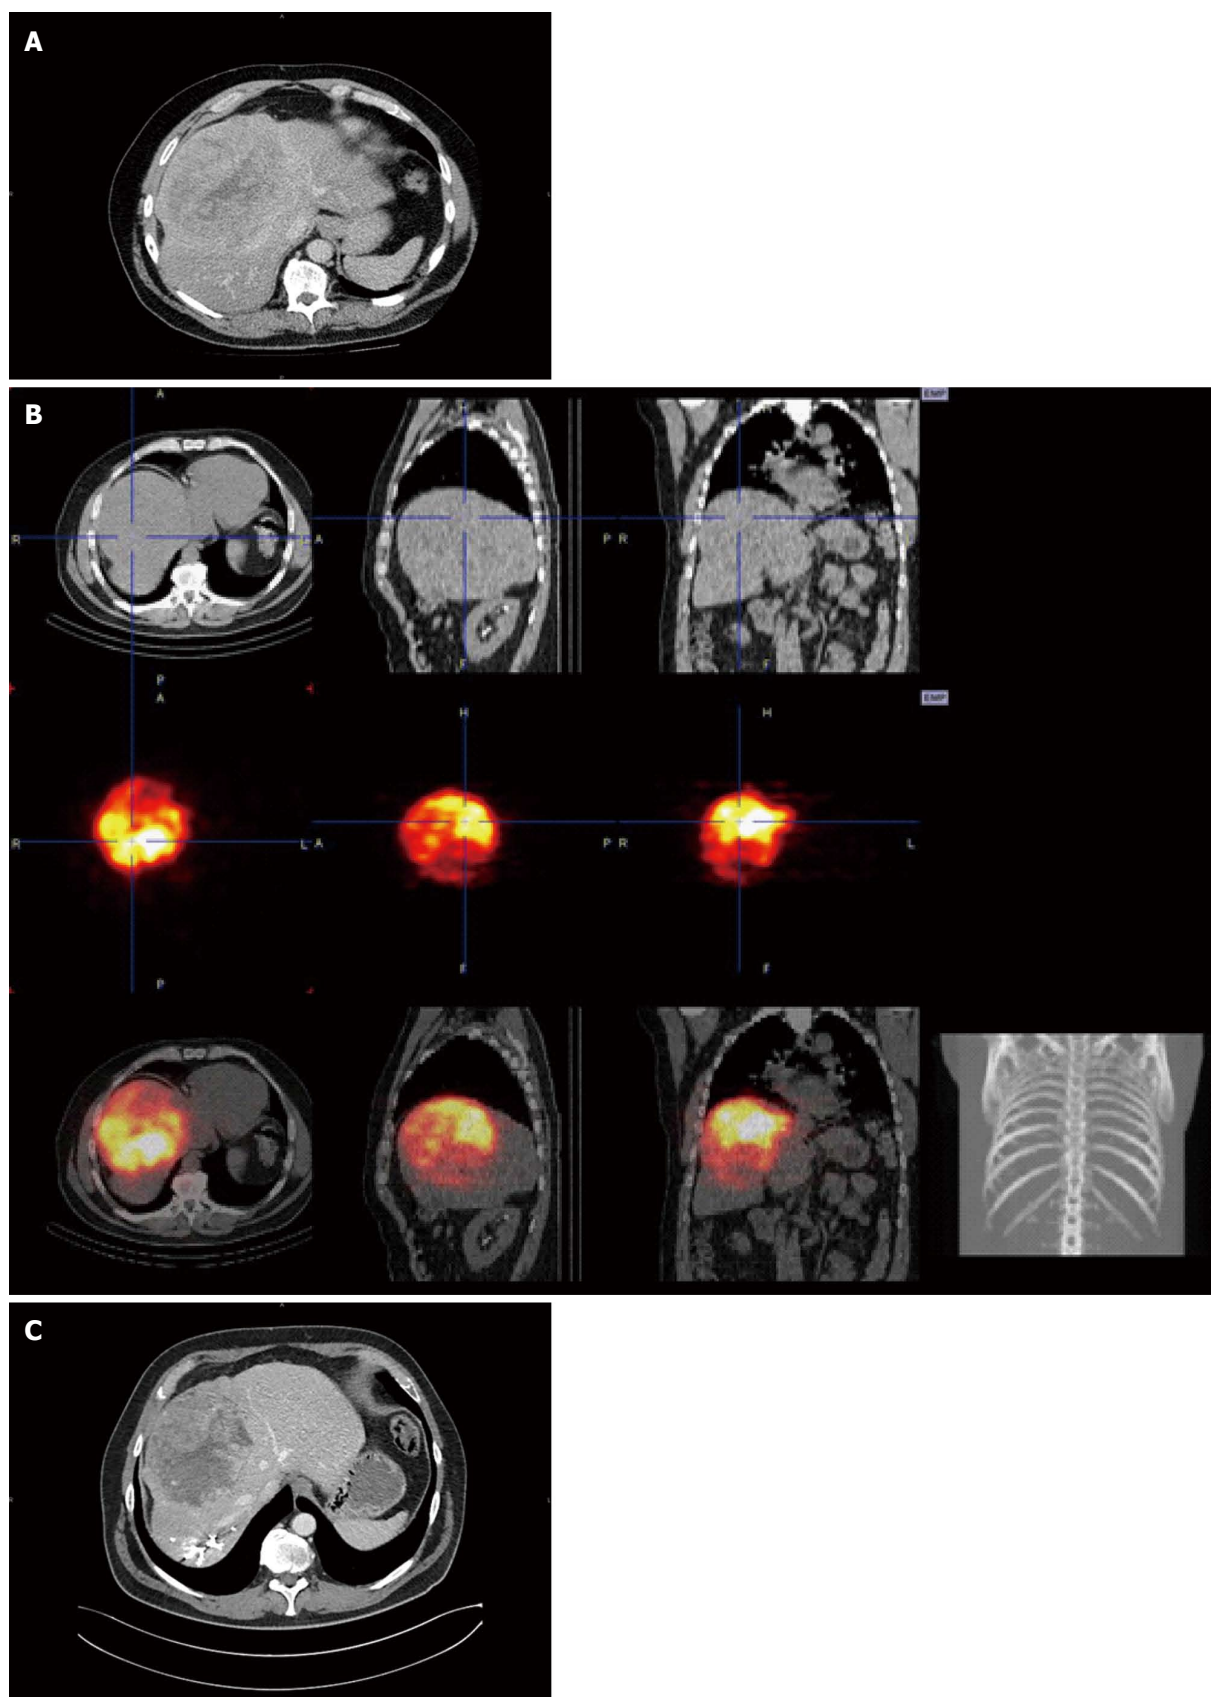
Tumor evolution throughout the therapeutic sequence. A: Contrast-enhanced computed tomography (CT) scan at presentation showing, in portal phase, a 167 mm tumor in segment VIII with features of hepatocellular carcinoma; B: Yttrium-90 (^{90}Y) positron emission tomography (PET)-CT performed 12 hours after transarterial radioembolization (TARE). Images are displayed in orthogonal views, centered on the liver tumor. Upper row: CT scan without contrast. Middle row: ^{90}Y emission PET images showing high and selective accumulation of ^{90}Y microspheres in the tumor site. Lower row: fused ^{90}Y PET-CT images; C: Contrast-enhanced CT scan 17 wk after TARE and 6 wk after portal vein embolization showing, in portal phase, a 50% tumor volume reduction and hypertrophy of the future remnant left liver.
